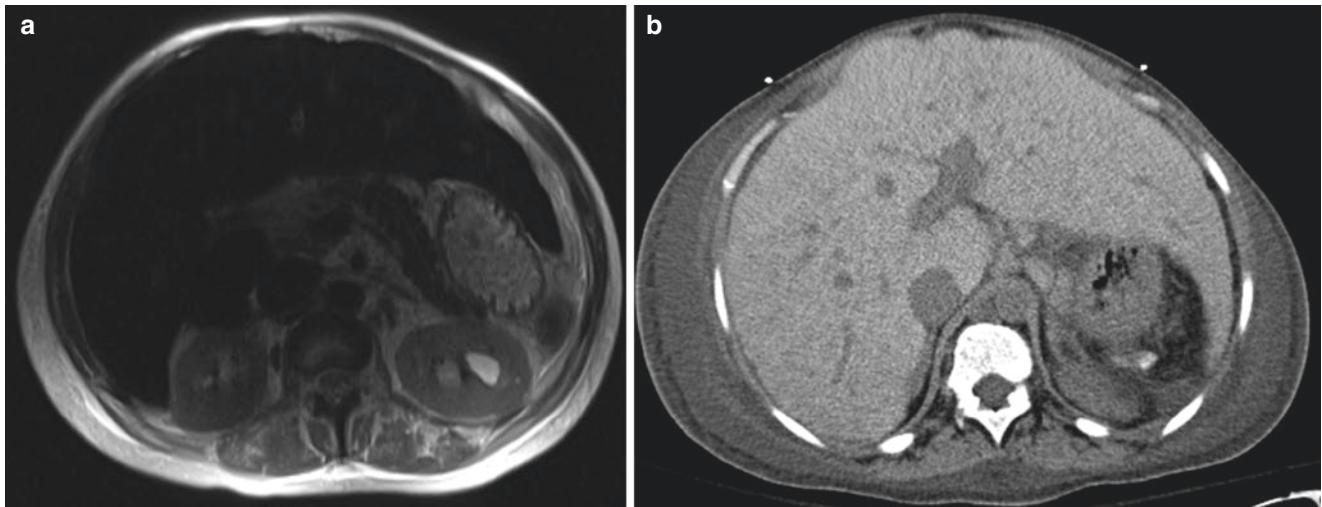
29-year-old female with long history of sickle cell anemia requiring multiple transfusions. Axial T2-weighted MRI demonstrates significantly decreased liver-signal intensity and NECT increased attenuation in the liver due to the iron overload
